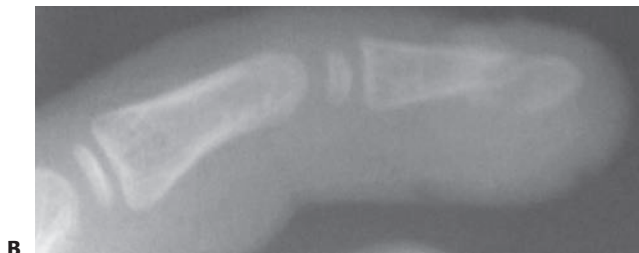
A: A crush injury to the thumb of a 4-year-old child with a stellate nail bed laceration and fracture of the tuft. B: Radiograph reveals a comminuted tuft fracture.
